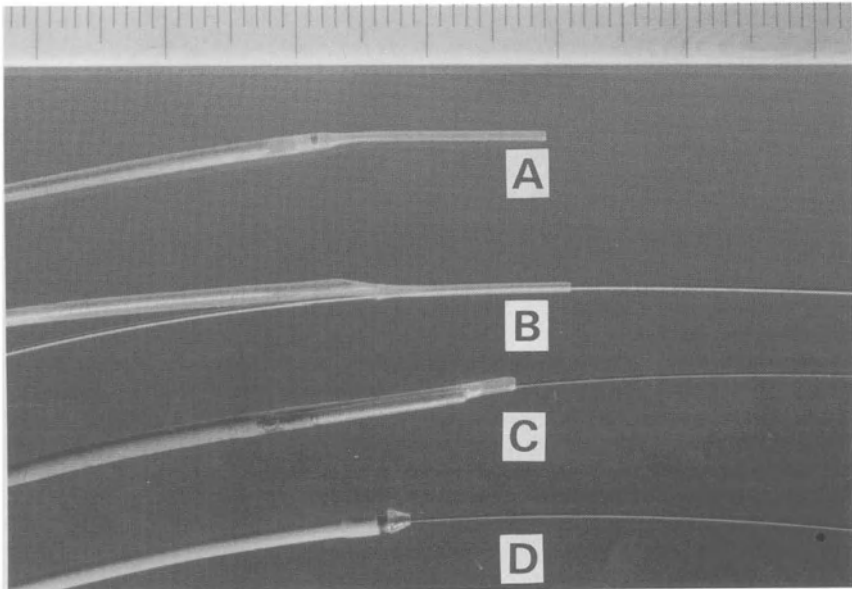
The distal end of four intravascular ultrasound coronary catheters is shown. A) Single element rotating mirror (arrow) catheter characterized by a completely independent external sheath and inner catheter; this system has the potential for an extreme miniaturization (3.5 French catheters are in clinical use) but has the limitation that the insertion of the guidewire requires the removal of the ultrasound catheter; B) rotating element 4.1 French 30 MHz ultrasound catheter, characterized by a very small Monorail lumen at the distal end (DuMed, Rotterdam, The Netherlands); C) Single element rotating mirror intravascular ultrasound catheter (Cvis, Sunnyvale, CA, USA) allowing the continuous use of a guidewire using a Monorail technique (diameter: 4.3 French); D) Multielement dynamic array catheter (a 5 French catheter is shown but 3.5 French catheter and combined balloon/ultrasound catheters are available, Endosonics, Costa Mesa, CA, USA); 64 elements are aligned circumferentially around the tip so that a central lumen is available for catheter insertion and the shaft can be very flexible because no driving cable is required; the small dimension of the elements, however, is responsible for a lower image quality in comparison with the mechanical scanners.
